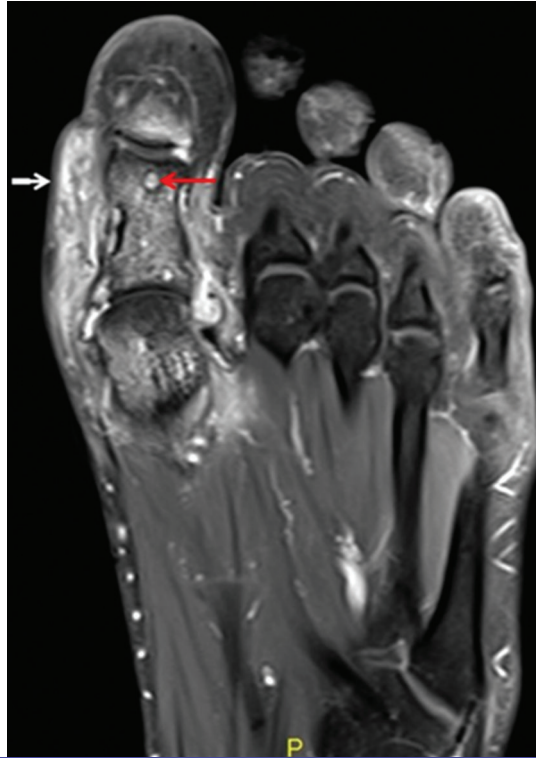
The post-contrast T1-weighted fat-saturated coronal image of the foot showing significant enhancement of soft tissue (white arrow) and mycetoma grains (red arrow).
